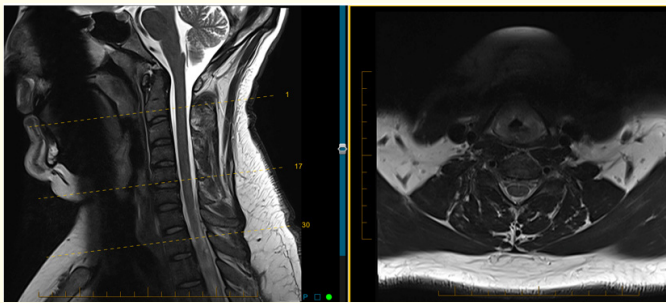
MRI Cervical Spine (6/3/18) Pre - op.
